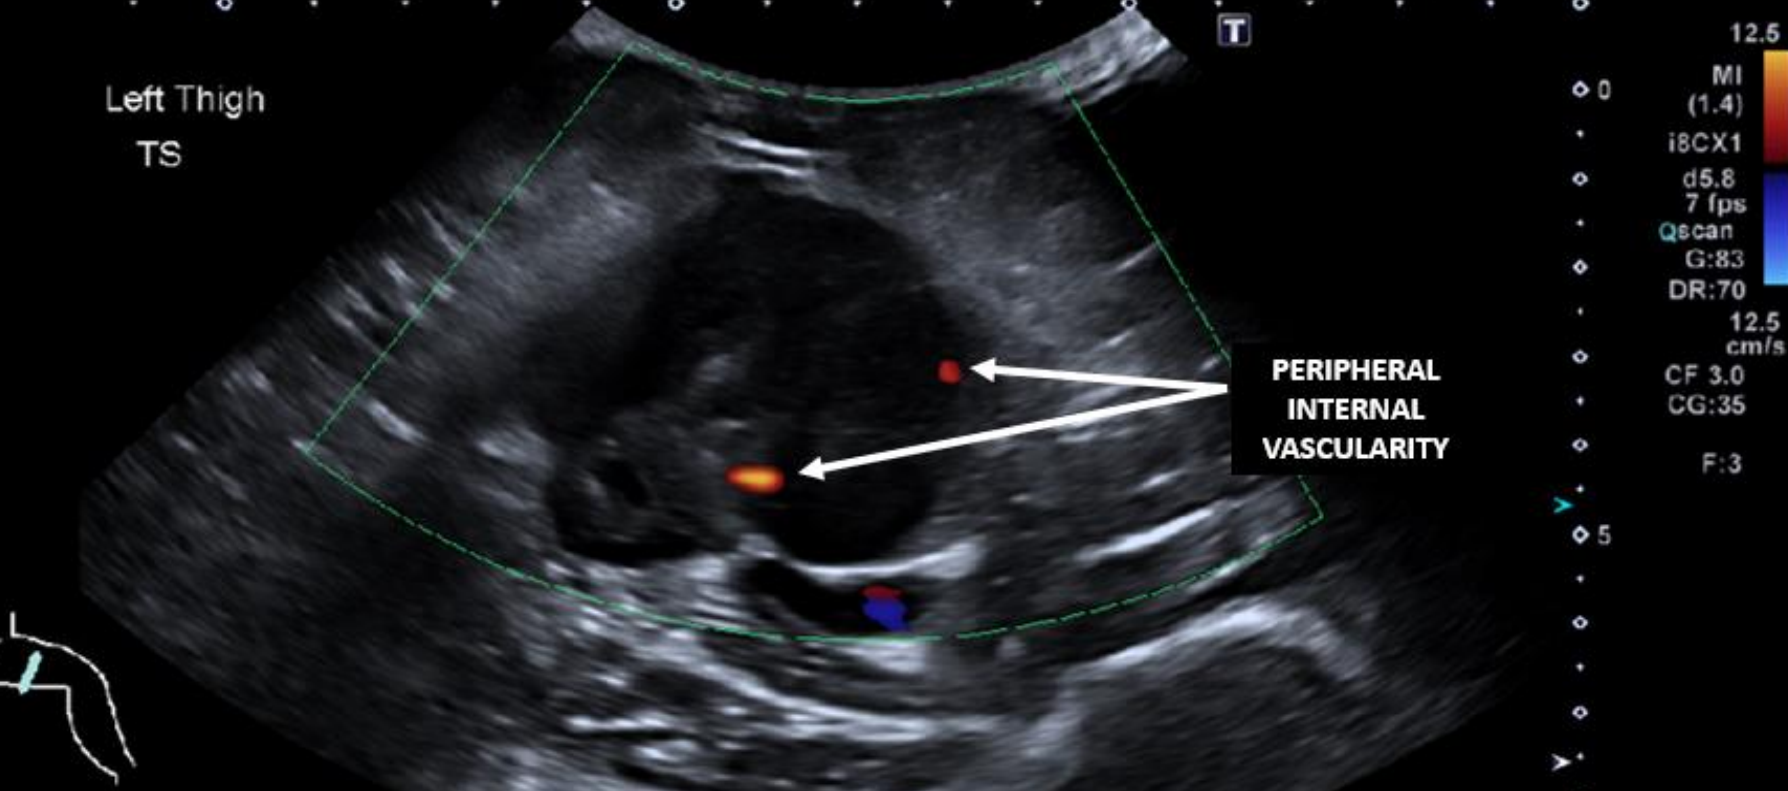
A solid, heterogeneous mass was identified. It was hypoechoic to surrounding muscular structures, well-circumscribed and expansile; typical sonographic findings of STS (Jacobson *et al.*, 2022). The mass was located anterior to the femoral vessels without obvious involvement. Vessel encasement is an independent predictor of local recurrence and has surgical implications (Crombe *et al.*, 2023).
